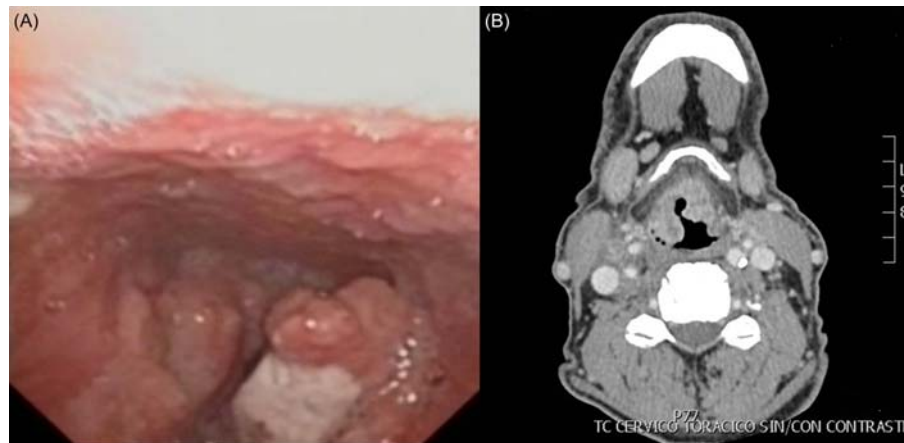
(A) Endoscopic view of the larynx showing a tumor of the supraglottic. (B) Axial contrast enhanced CT showing an advanced supraglottic carcinoma. Moderately thick lesion arising from laryngeal surface of epiglottis with involvement of preepiglottic space.
